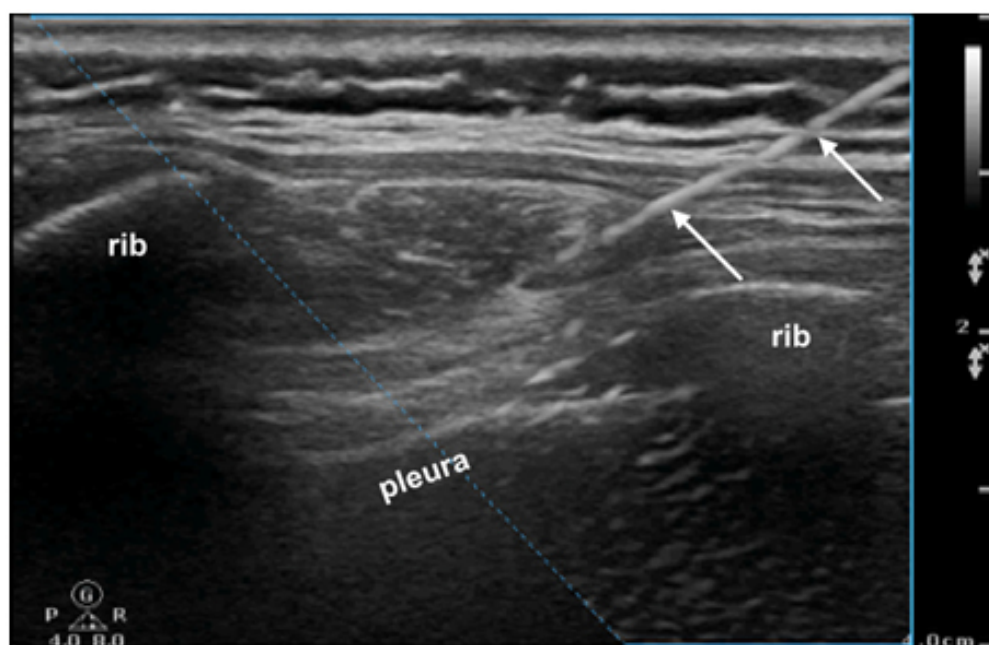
Sonogram showing needle using an in plane insertion approach (Vandepitte et al., 2013).
